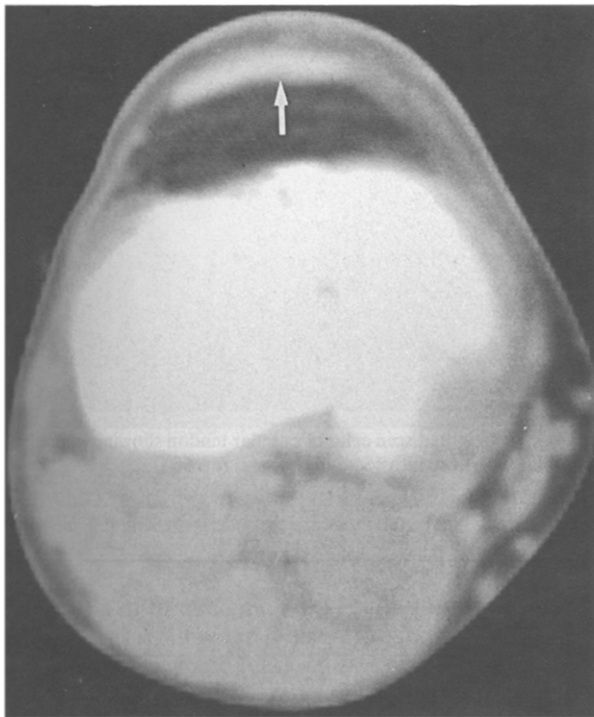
CT scan of the normal patellar ligament (white arrow).
